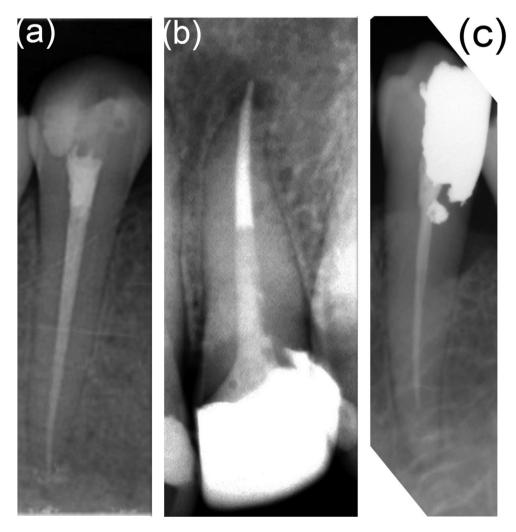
Representative periapical radiographic images of the individual parameters evaluated in the current audit: (a) acceptable density, taper, and length, (b) overfilled root canal, and (c) unacceptable density, taper, and length.
